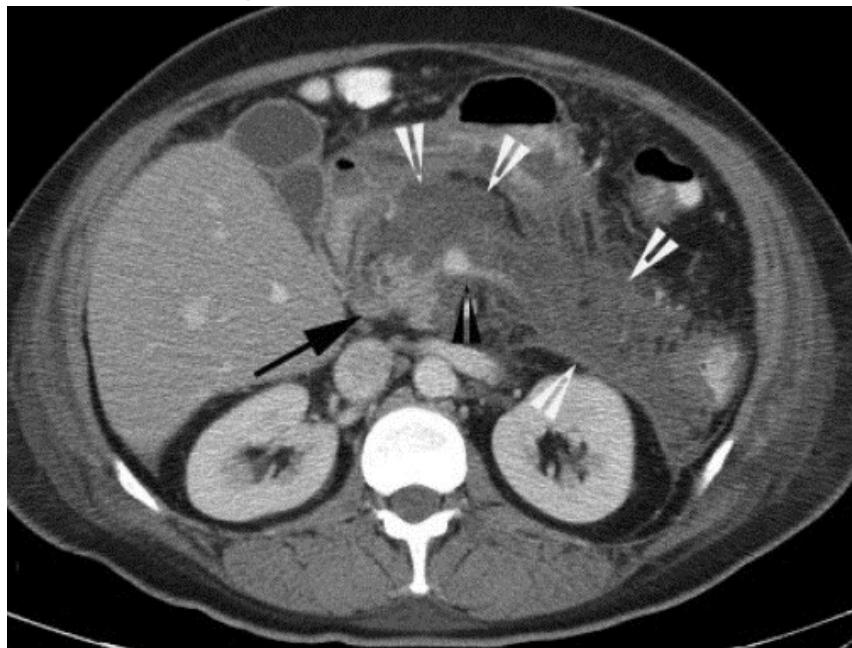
Contrast-enhanced CT of acute necrotizing pancreatitis. *The black arrowhead notes the junction of the superior mesenteric and splenic veins. The normal pancreas should be seen enhancing anterior to this. Non-enhancing pancreas can be seen in this case (white arrows). Normal enhancing head is seen (black arrow).*
